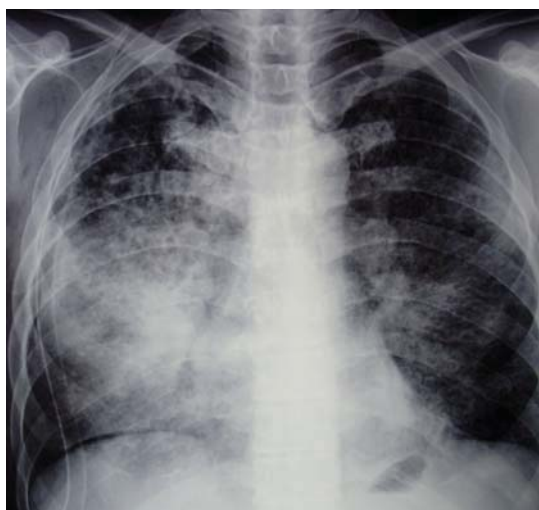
The fourth postoperative day: progression of radiographic changes
